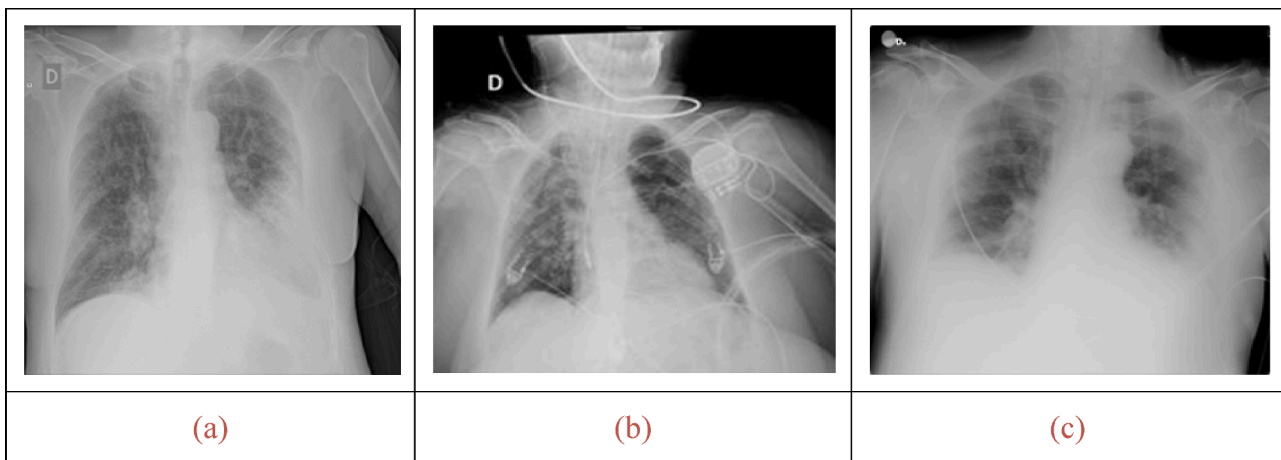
Images present in the COVID-19 radiography database. (a)-(c): Sample images 1–3.
